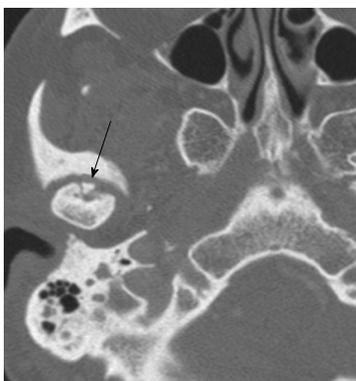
Osteochondritis dessicans. Axial computed tomography scan through the level of the temporomandibular joint demonstrates a tiny bone fragment (arrow) at the anterior aspect of the disk. It can be noted that there are linear lucency surrounding the bone fragment.
